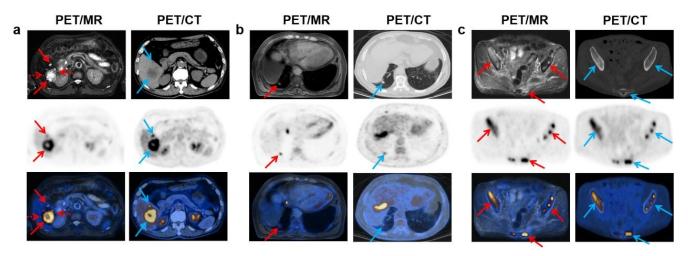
Detection of distant metastasis. (a) Liver metastasis detected on both PET/MR (red arrow) and PET/CT (blue arrow). Positron emission tomography/MR shows clear boundaries and internal morphology and detects more tiny lesions (red dashed arrow); (b) PET/MR (red arrow) and PET/CT (blue arrow) both displayed a lung metastatic lesion; (c) PET/MR (red arrow) and PET/CT (blue arrow) both showed metastases on bilateral iliac and sacral bones.
